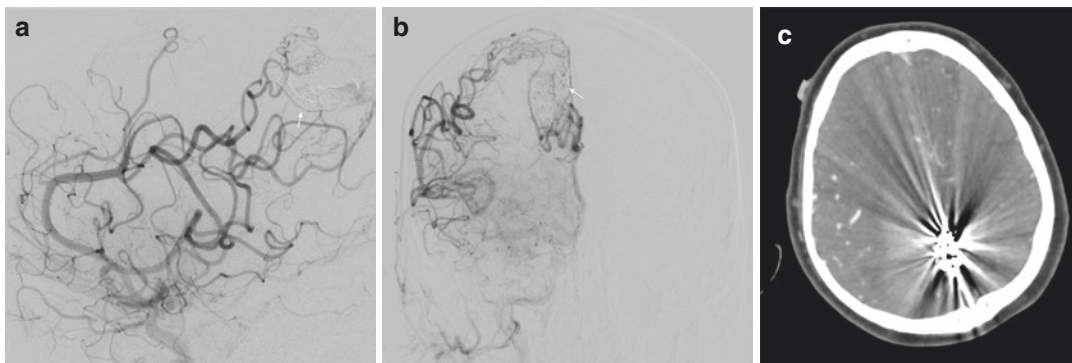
(a, b) Conventional DSA showing the same AVM shown in Fig. 12.1 has been embolized using Onyx (white arrow). (c) CT scan showing embolization of the same AVM
